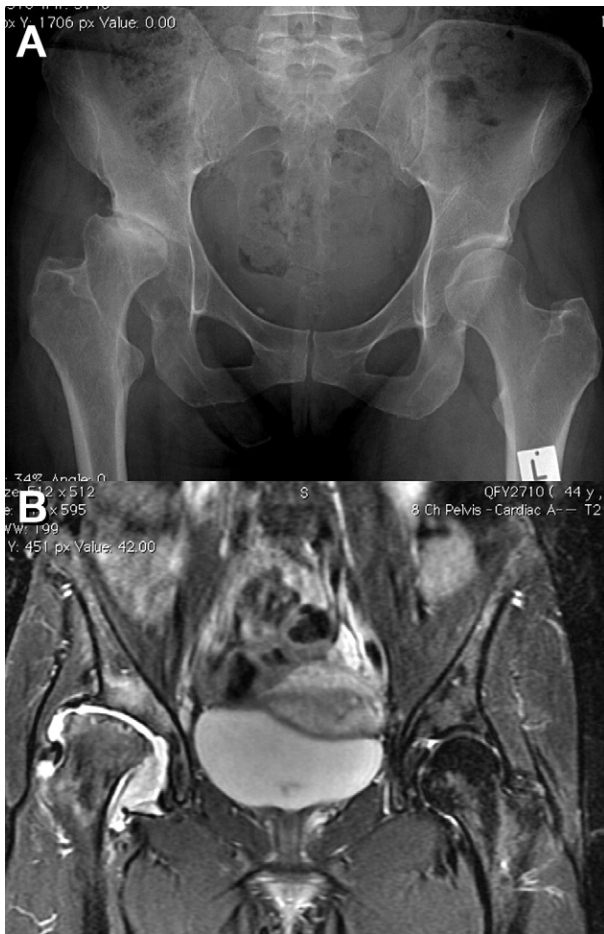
One year after hip arthroscopy, labral repair, and partial LT debridement, (A) the anteroposterior pelvis radiograph and (B) coronal MRI study show complete loss of joint space with marked flattening and sclerosis of the femoral head and sclerosis of the acetabulum.
